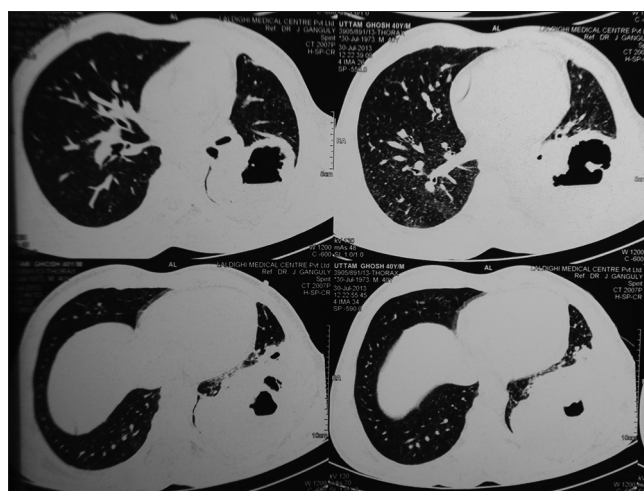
Computed tomography thorax cut showing thick wall cavitary lung mass
